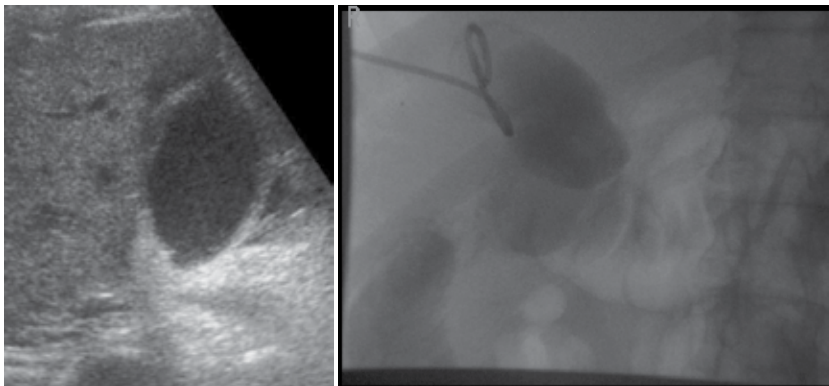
Elderly male patient developed cerebral infarction 2 days after undergoing aortic valve replacement. His recovery was further complicated by acute cholecystitis, as demonstrated by right upper quadrant ultrasound showing distended gallbladder with wall thickening, sludge and pericholecystic fluid (left). His operative risk for cholecystectomy was prohibitive at that time, prompting the placement of percutaneous cholecystostomy (right). Following good functional recovery and hospital discharge, the percutaneous drain was removed and the patient underwent elective laparoscopic cholecystectomy.
